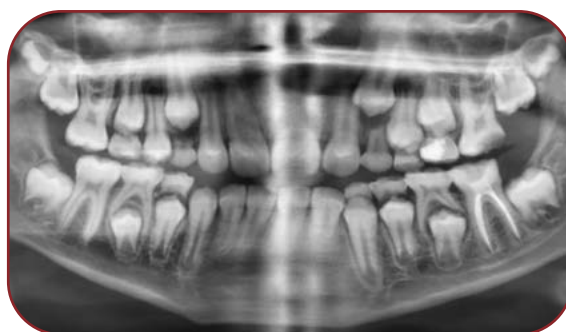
Caries with pulp involvement after treatment in tooth 36, on the orthopantomography (OPG) image, in a girl aged 10 years and 11 months
